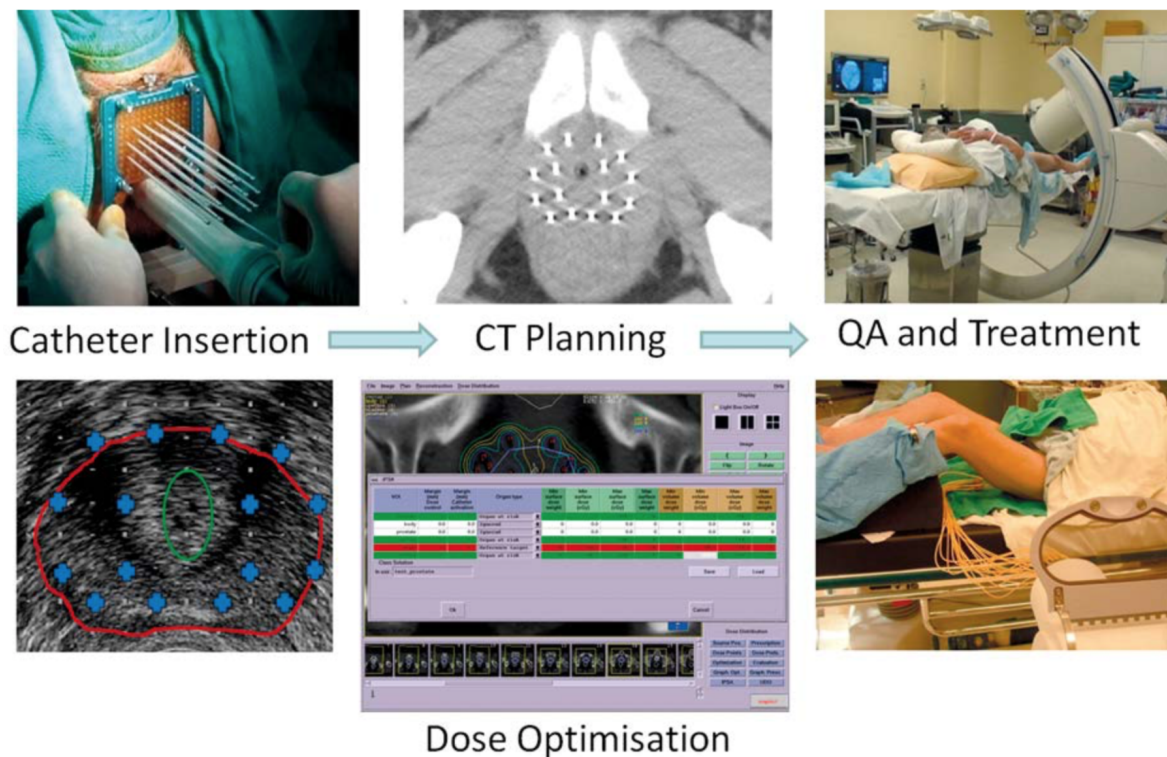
In a CT-based HDR-BT treatment for prostate cancer, catheters are inserted using TRUS imaging modality as the guidance. In order to acquire CT images for planning, the patient legs are lowered, or, in some clinics, the patient is transferred to a different room. After the plan optimization, and before delivering the treatment plan to the patient, corrections for any catheter displacement caused by the changes in the position of the patient is needed. For that reason, quality assurance (QA) in CT-based planning is significant (50).
